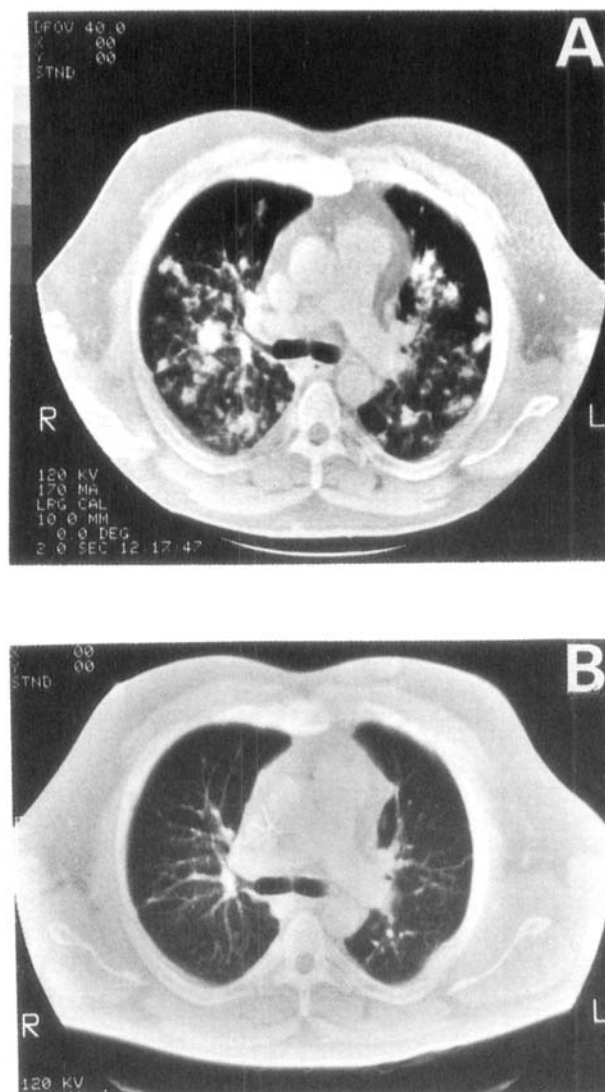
Chest CT-scan, A) at presentation, and B) 15 months after starting treatment.
